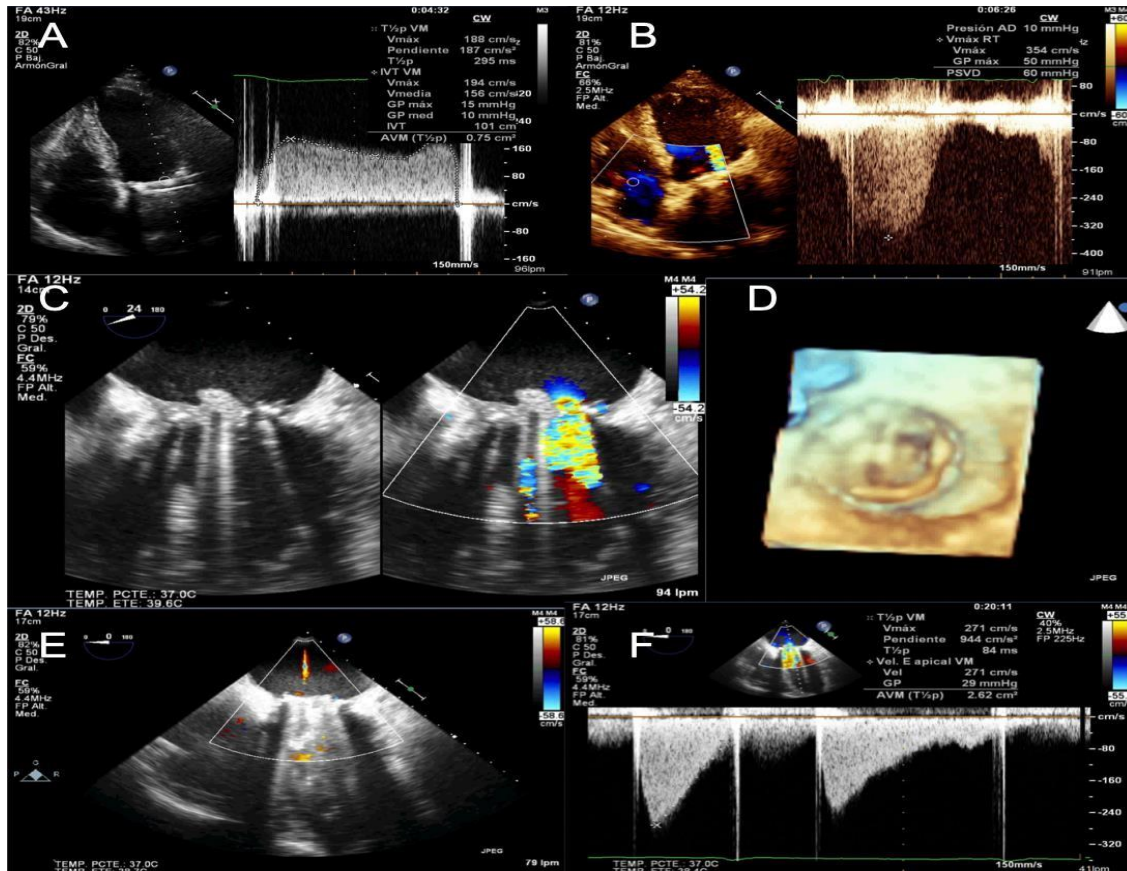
Bidimensional, color and continuous Doppler. A- Apical four chamber view showing prosthetic mitral stenosis with valvular area of 0.75 cm^2 and mean diastolic gradient of 15 mmHg . B- Moderate pulmonary hypertension with systolic pulmonary artery pressure of 60 mmHg . Bidimensional with color flow and three-dimensional transesophageal echocardiography showing: C- intraprosthetic vegetations and on the auricular side of the mitral prosthesis with dehiscence of mitral annulus of approximately 50% (D). E- Four chamber view bidimensional and color flow without evidence of mitral prosthetic valve vegetations. F- with continuous Doppler the mitral prosthetic valvular area was of 2.62 cm^2
